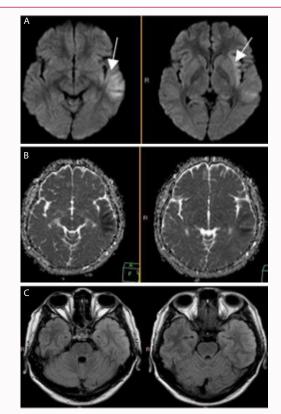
MRI brain showing diffusion restriction in Diffusion Weighed axial Images (DWI) at Left insular cortex (A). ADC map showing low intensity signals at Left insular cortex (B). Normal T2 FLAIR (C).
